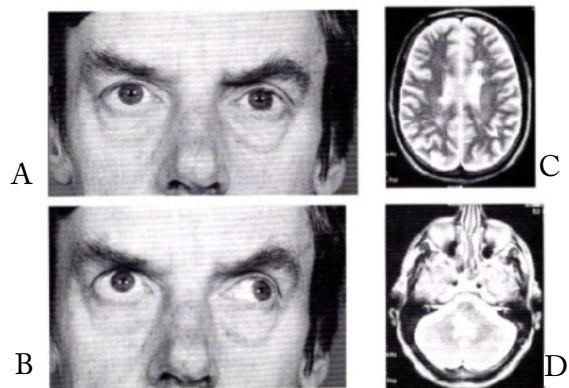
One-and-a-half Syndrome (A) Gaze to the right (absent); (B) Gaze to the left (abduction only). MRI View (C) Cerebral white matter abnormalities and the (D) Pontine lesion responsible for the eye movement disorder. Reprinted with permission from McAlpine's Multiple Sclerosis Churchill Livingstone.
